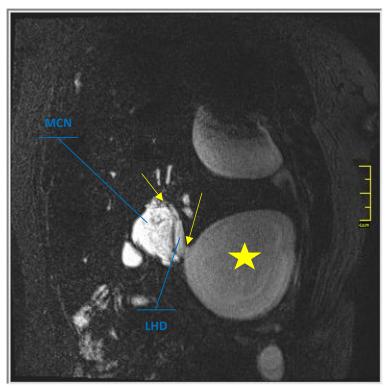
Oblique coronal T2-weighted MRI indicating the communication (arrows) between the MCN-L, left hepatic duct and the fluid collection (star).
